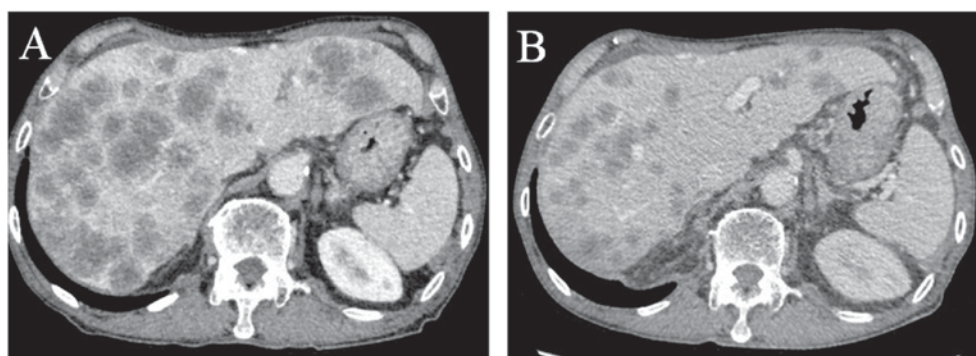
CT scan pre- and post-chemotherapy. (A) CT image of multiple liver metastases following two cycles of 5-fluorouracil, leucovorin, and oxaliplatin. (B) Multiple liver metastases exhibited a marked decrease of 45.1% (Response Evaluation Criteria In Solid Tumors, version 1.1) following treatment with cisplatin and etoposide. CT, computed tomography.
